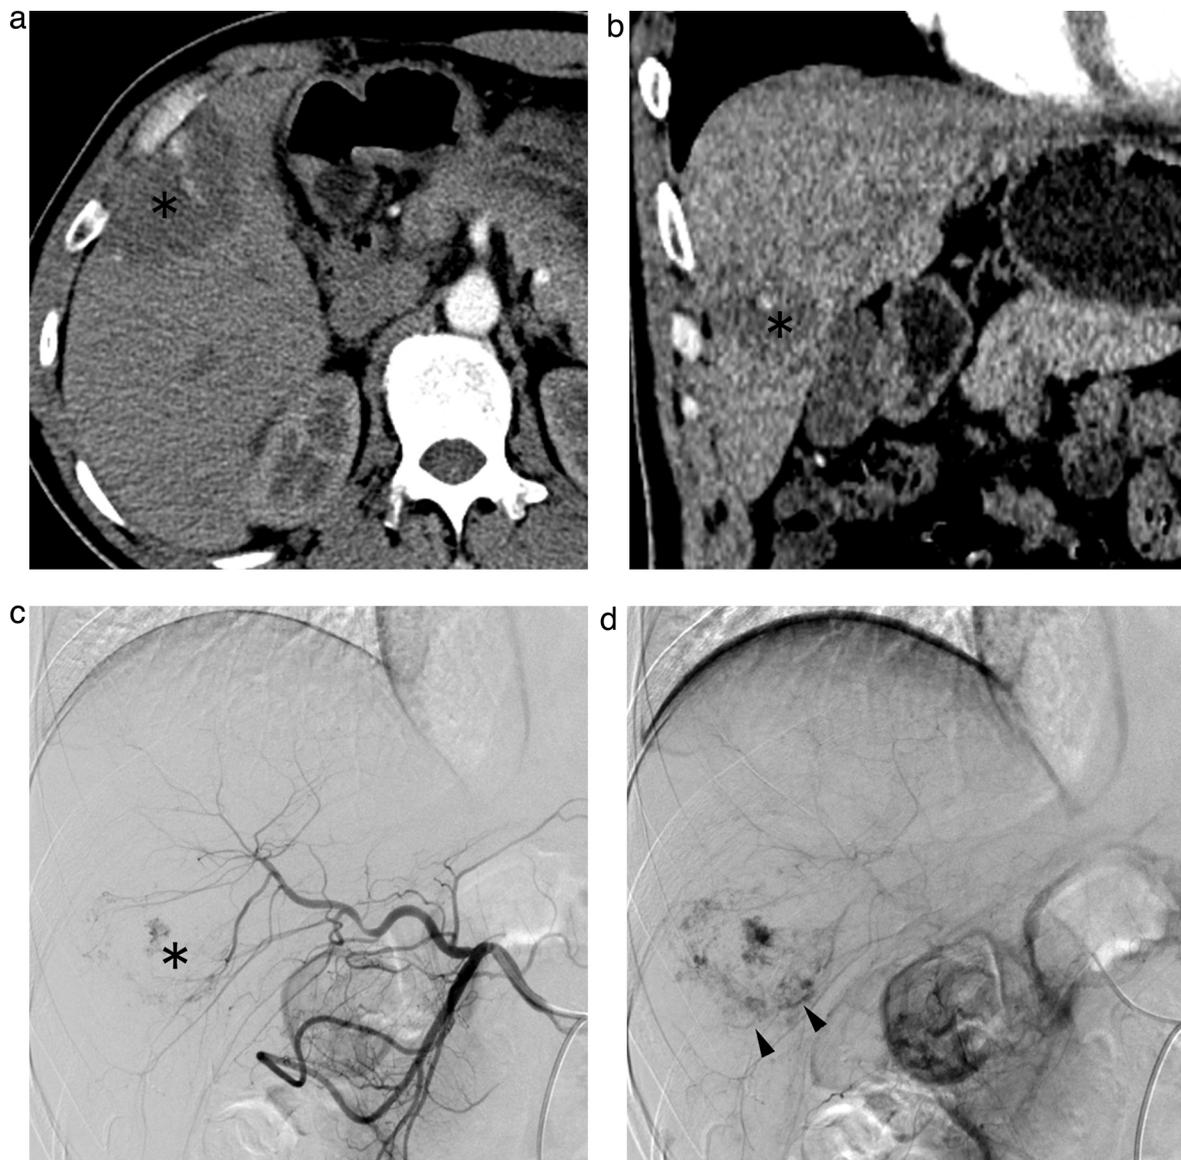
Peripheral APS associated with a HH. (a,b) Contrast-enhanced axial (a) and coronal (b) CT images obtained during the hepatic arterial phase show a HH lesion (asterisk) in segment V, without any early enhancement of the peritumoral parenchyma. (c) Selective common hepatic arteriogram obtained during the early arterial phase confirms the HH (asterisk) in the right liver lobe. (d) Arteriogram obtained during the late arterial phase shows the early opacification of a tubular vascular structure (arrowhead) around the lesion, which is suggestive of a portal vein branch.
